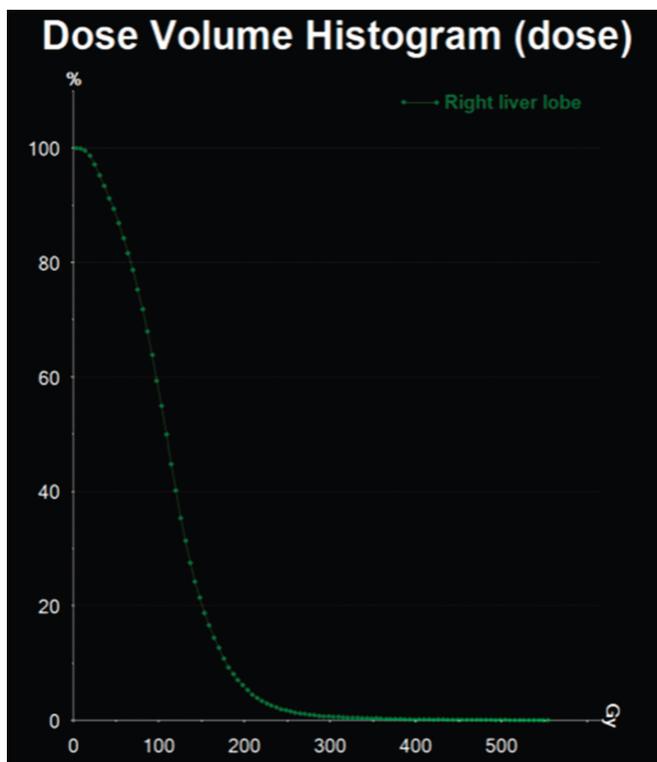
The dose-volume histogram is shown in Figure 2. Within the segmented volume of interest, the calculated maximum lesion dose of 276 Gy (Fig. 1D) is higher than data published by other authors who found maximum lesion doses up to 238 Gy in single time point estimations⁸ The same is true for the healthy liver tissue, where we found doses of up to 45 Gy, whereas other authors⁸ report up to 33.8 Gy. This difference might be at least partially attributed to the different geometry and properties of the glass spheres used in our institution compared to the ⁹⁰Y-labeled resins used in other publications. However, a cross-validation study with SPECT/CT and PET/CT is warranted and subject to ongoing research.
